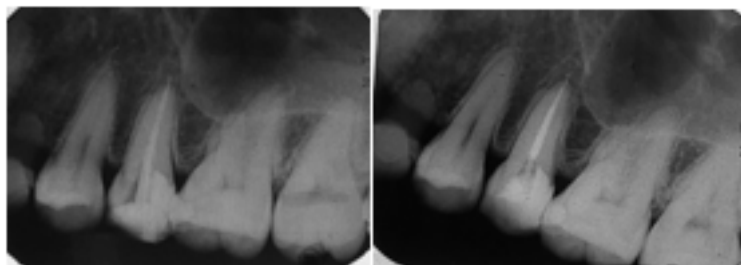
Trial Radiographic Photo and After Obturation Radiographic Photo
